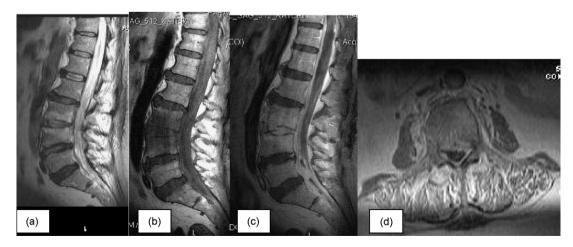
Follow-up MRI at 6 weeks from patient 6: sagittal T2 (a), T1 (b), and post-gadolinium sagittal (c) and axial (d) T1 images show improvement of the intervertebral disc signal on T2 images, more extensive bone marrow edema of the L3–L4 vertebral bodies, more extensive post-gadolinium enhancement of the vertebral body and the intervertebral disc, but improvement of the epidural and paraspinal abscesses.
